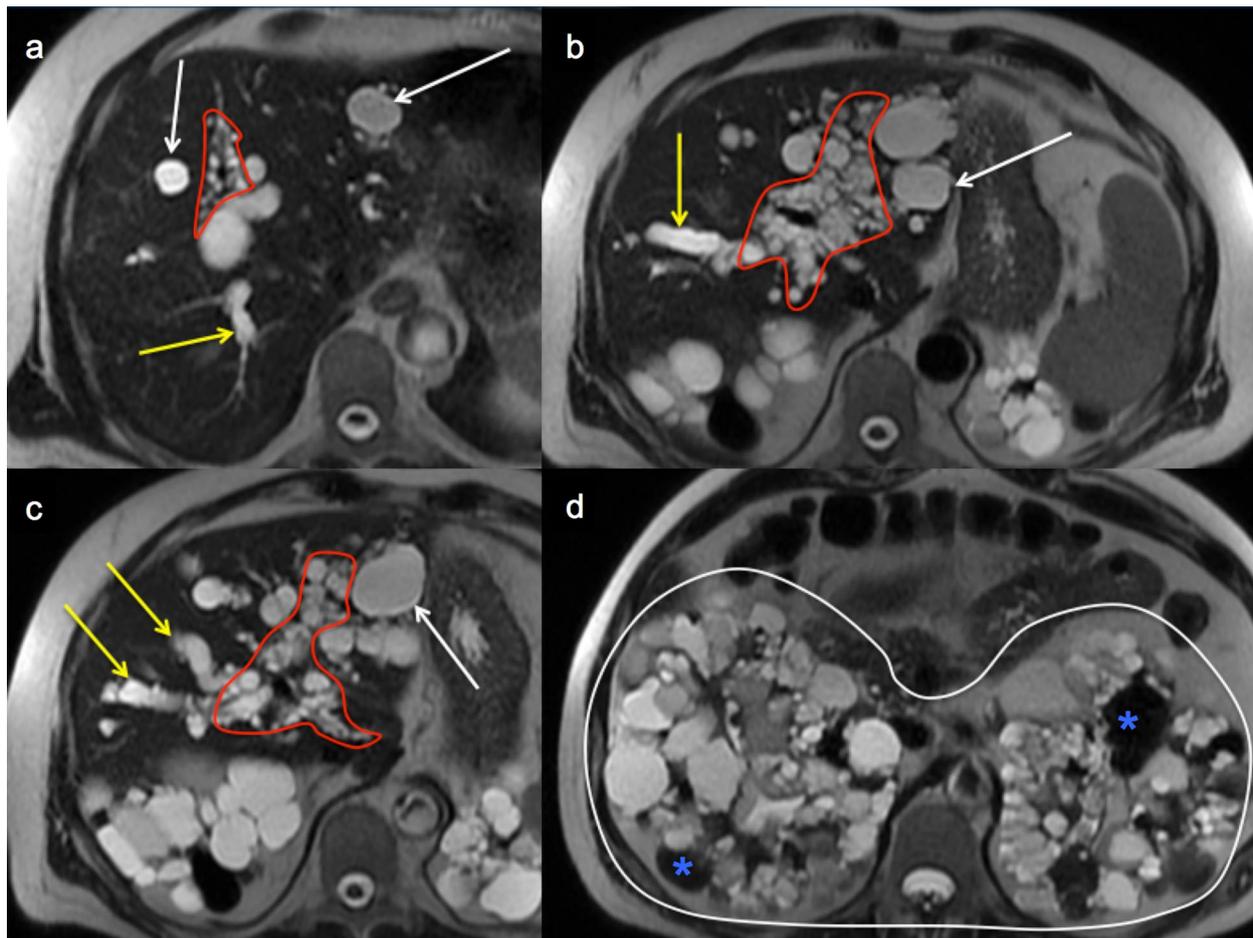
Polycystic liver disease. Axial T2-w MR images show intrahepatic cysts (white arrows) and peribiliary cysts (red lines) in patient with ADPKD. Notice the coexistence of Caroli disease (yellow
